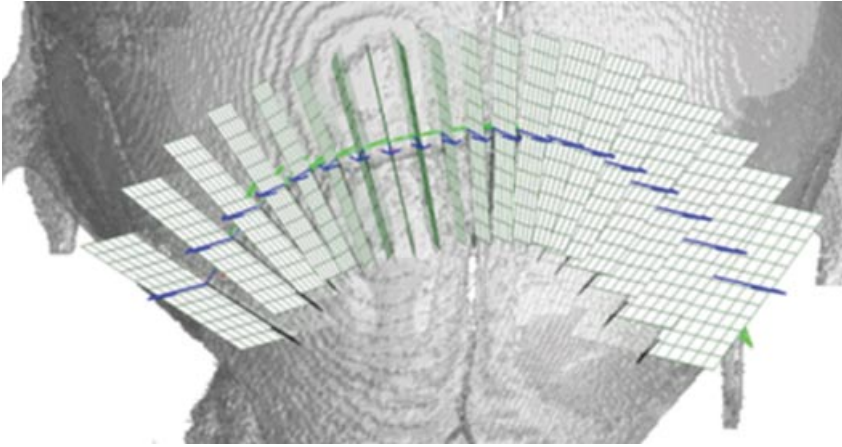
Morphometric analysis of three-dimensional computed tomography reconstruction. Advanced reconstruction and segmentation algorithms allow for thorough analysis of complex structures commonly seen in craniofacial bones. These analytical techniques can lead to more anatomically precise bioengineered bones.
